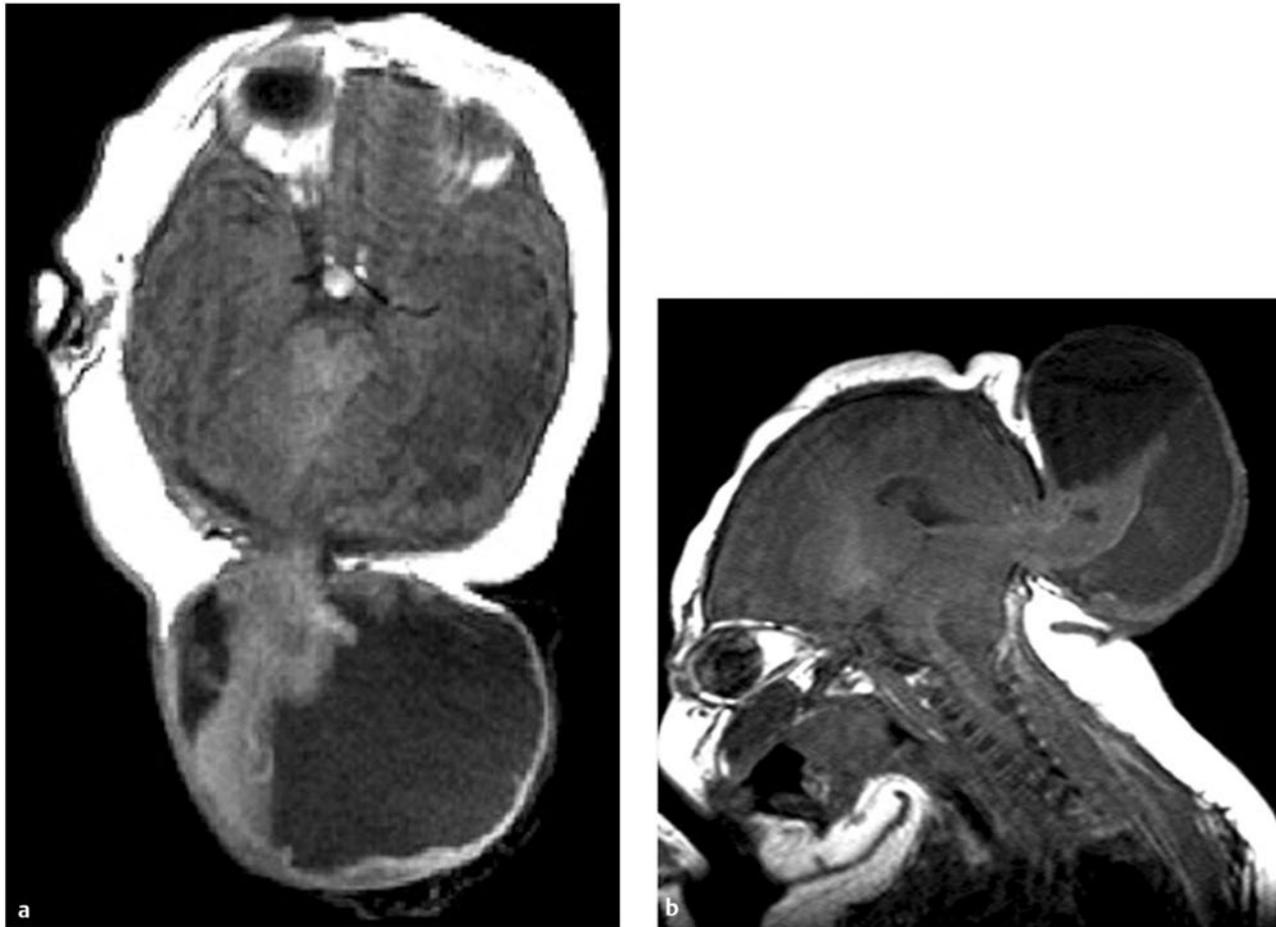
Axial T1-weighted (a) and sagittal T1 weighted (b) magnetic resonance images of a newborn with occipital cephalocele show suboccipital cranial defect and herniated cerebellum.
